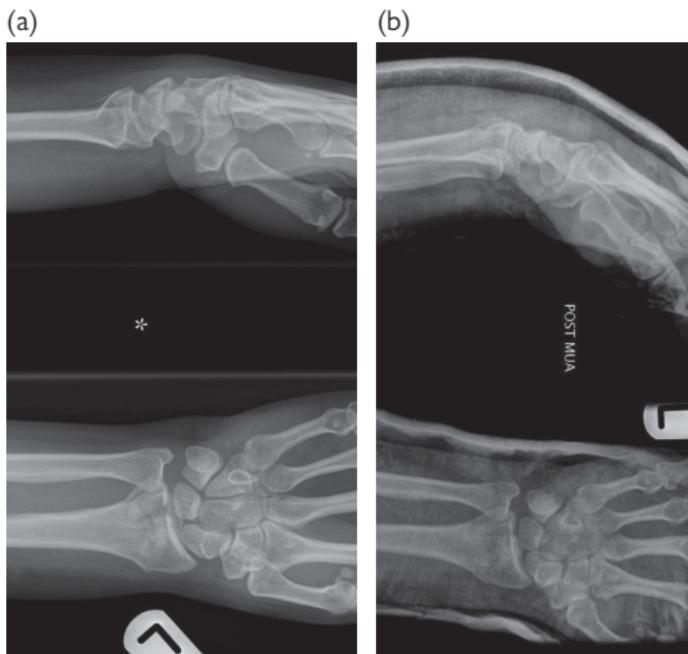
X-rays of angulated Colles' fracture before (a) and after (b) manipulation.
